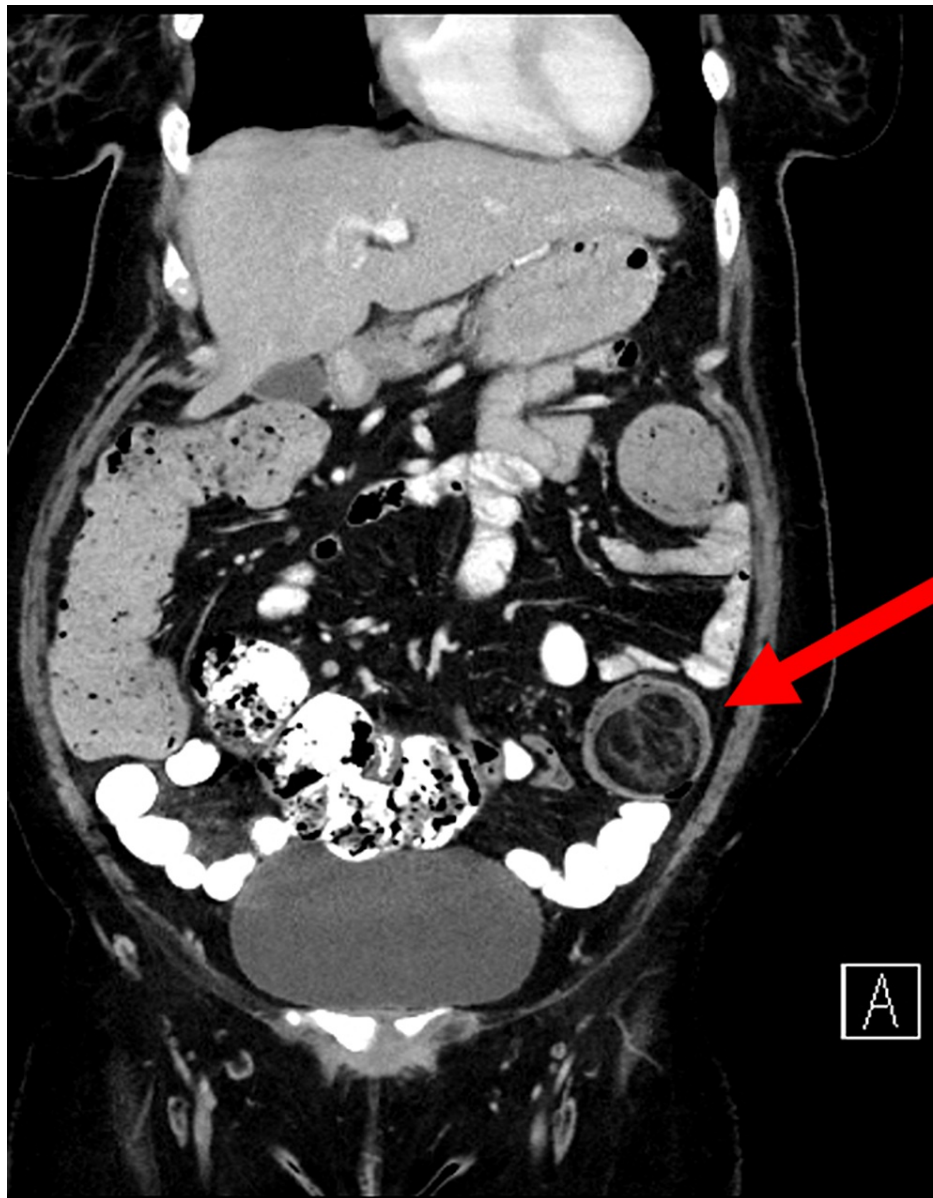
Coronal CT scan showing lipoma
